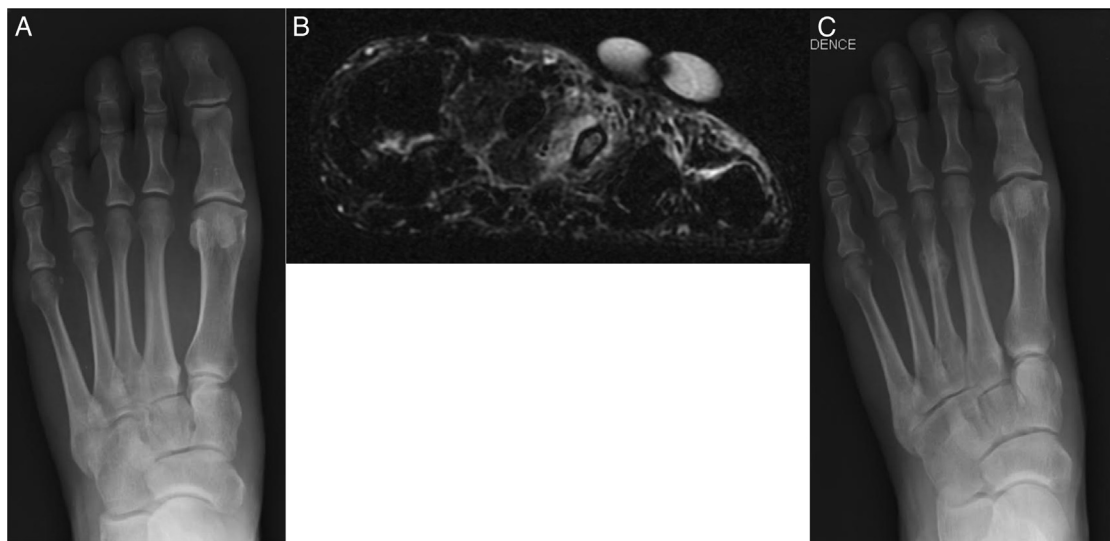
A 51-year-old female presented with forefoot pain associated with weightbearing. The initial radiograph (A) did not display an acute fracture. The patient underwent subsequent magnetic resonance imaging (B), in which an increased signal in the bone marrow of the third metatarsal and surrounding soft tissues, consistent with a stress fracture, was seen on T₂-weighted and short T₁-weighted inversion recovery images (shown on coronal T₂-weighted images). The patient's serum 25-hydroxyvitamin D level was 33 ng/mL, and she was prescribed vitamin D₃ 4000 IU daily. A follow-up radiograph (C) displayed circumferential callus formation after the patient had been placed in a fixed-walking boot for 6 weeks.
